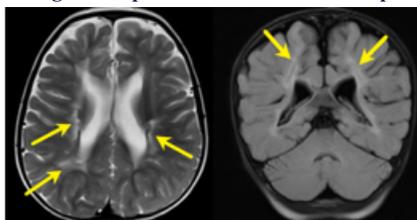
Axial T2WI and FLAIR coronal image of 3yr old female with history of preterm delivery shows periventricular hyperintense signal with prominence of bilateral lateral ventricles.
